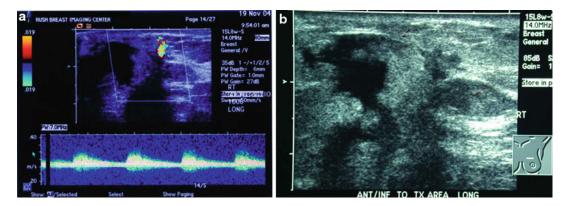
Color Doppler appearance of neo-vascular: (a) *left image*, generated six months before detection of local recurrence shown on (b) *right image*
